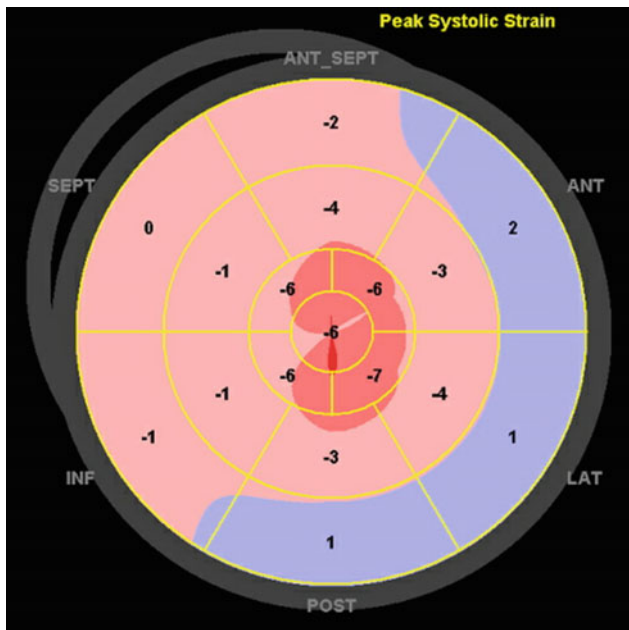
Strain echocardiogram showing decreased global longitudinal strain (-1.6%) with a relative apical sparing pattern
